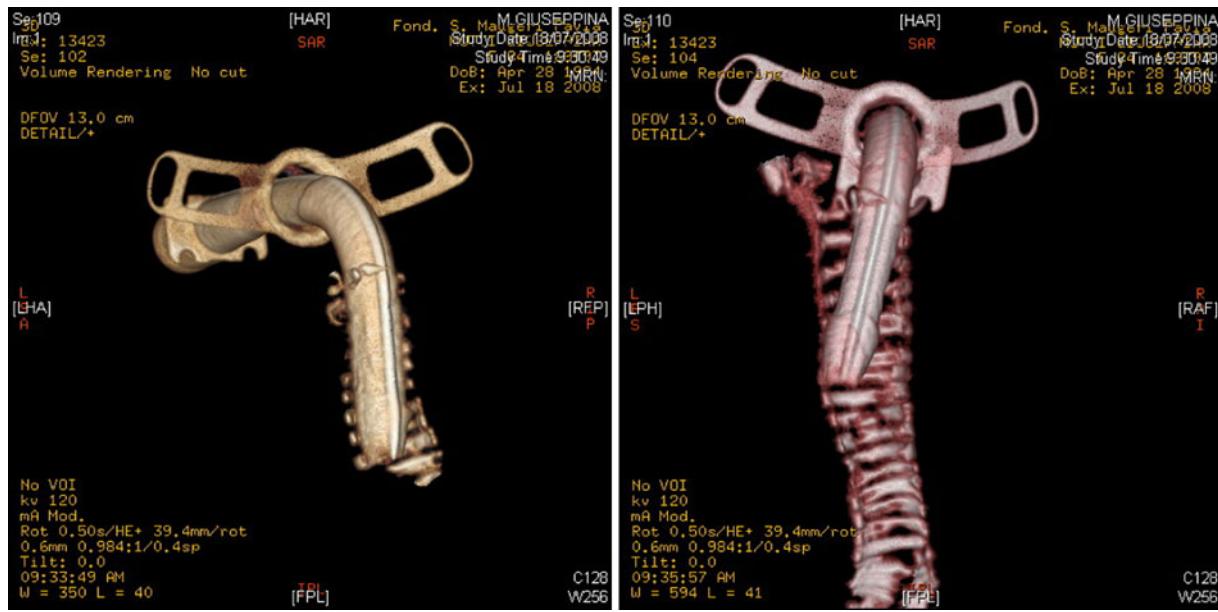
Three-dimensional CT reconstruction of the trachea from a longitudinal view. Fig. 1 When the tracheal tube cuff is deflated, the tube maintains its correct position along the tracheal
